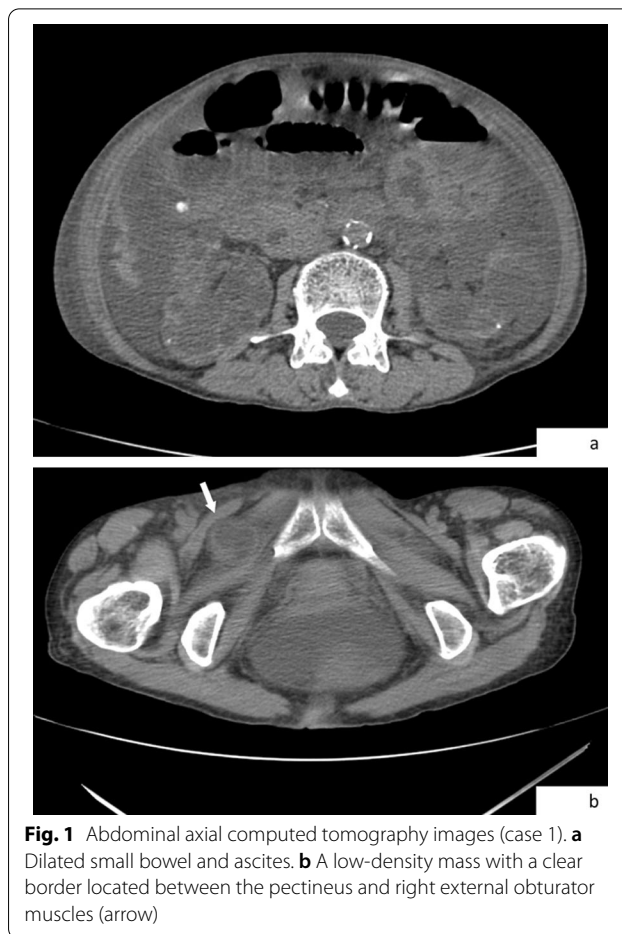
Abdominal axial computed tomography images (case 1). a Dilated small bowel and ascites. b A low-density mass with a clear border located between the pectineus and right external obturator muscles (arrow)
